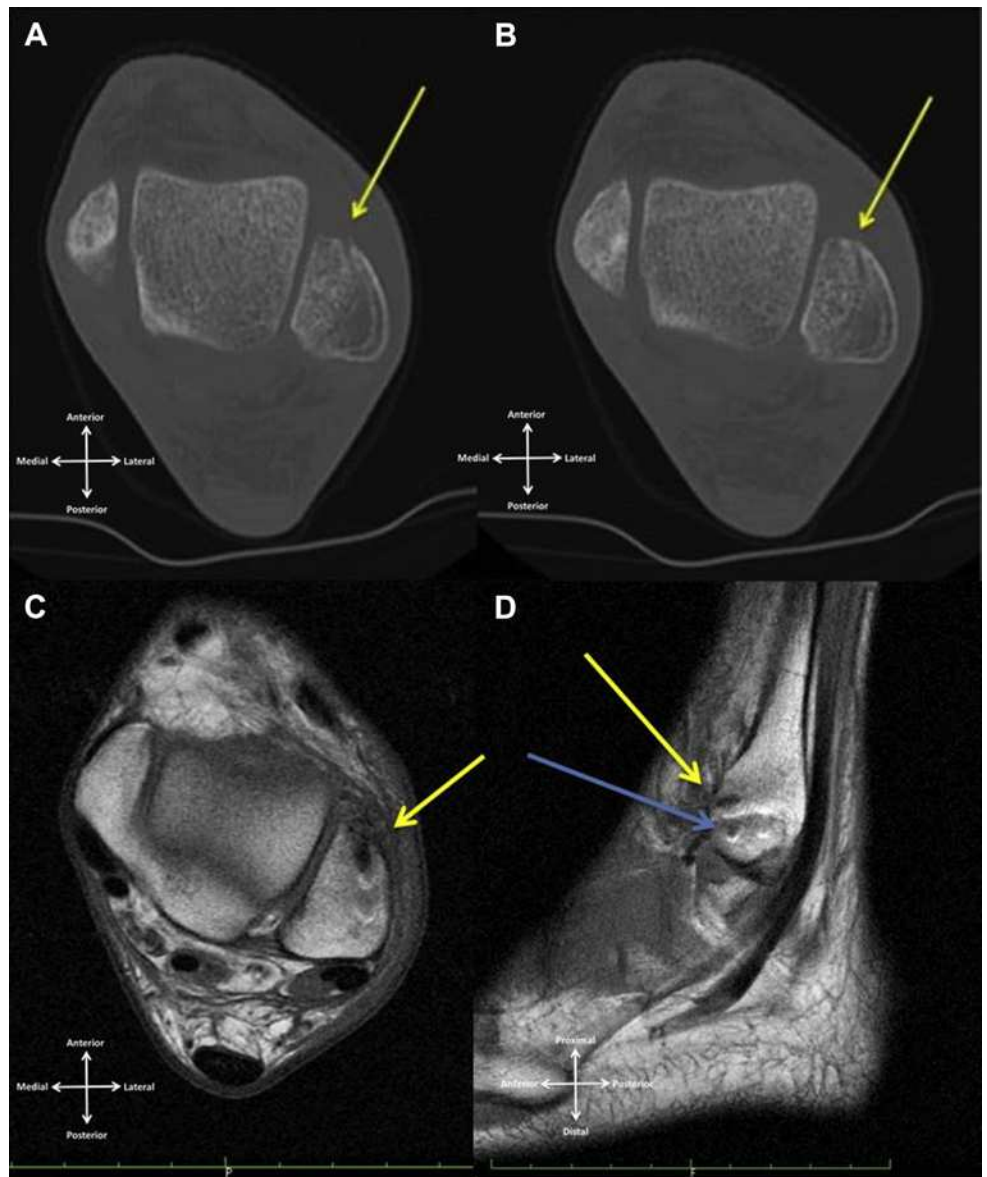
(A, B) Computed tomography evaluation of a left ankle showing the small defects (yellow arrows) caused by the 2.1-mm anchors 2 months postoperatively. (C, D) Magnetic resonance imaging T1 evaluation of left ankle 2 months postoperatively. Some signal changes are explained by the short interval from surgery. (D) On the sagittal view, both tunnels can be identified (blue and yellow arrows).
